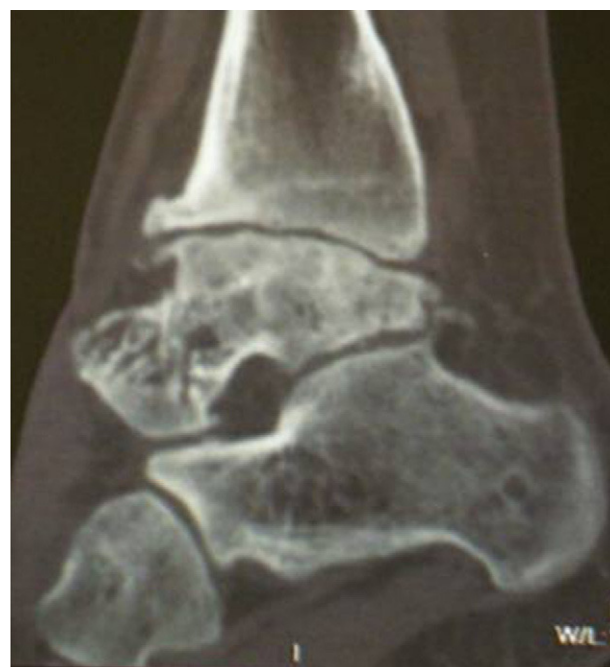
Computed tomography of the left ankle.
